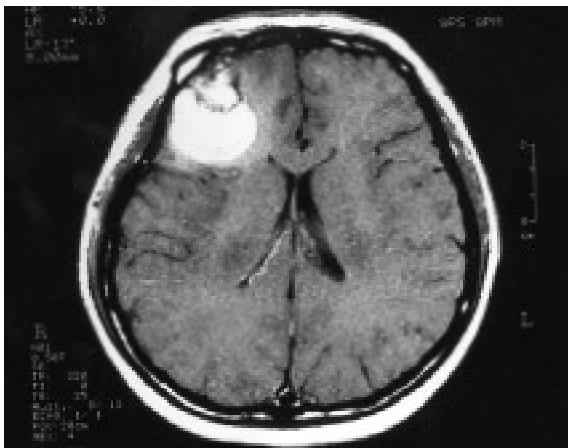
Axial enhanced T1-weighted MR image.
